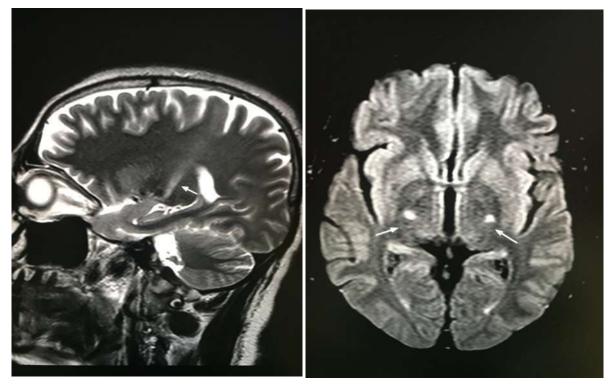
T2WI and DWI in Sagittal and Axial planes showing high intensity signals in corticospinal tract (internal capsule).
